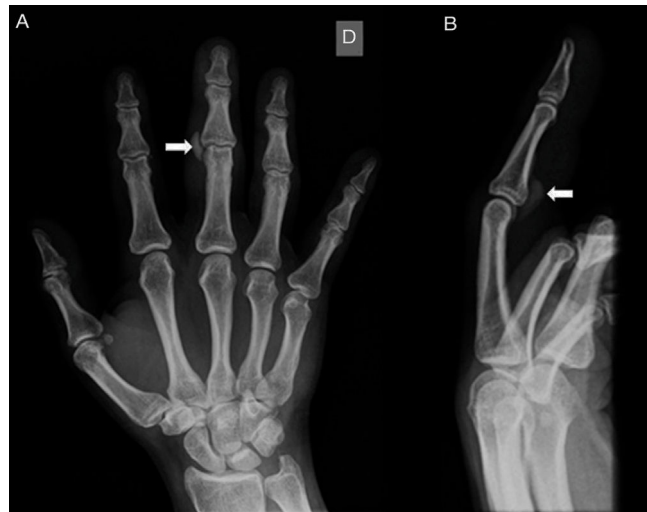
Anteroposterior (Panel A) and lateral (Panel B) radiographs showing well-circumscribed calcification over the radial and volar aspect of the right third finger proximal interphalangeal joint (arrows).
